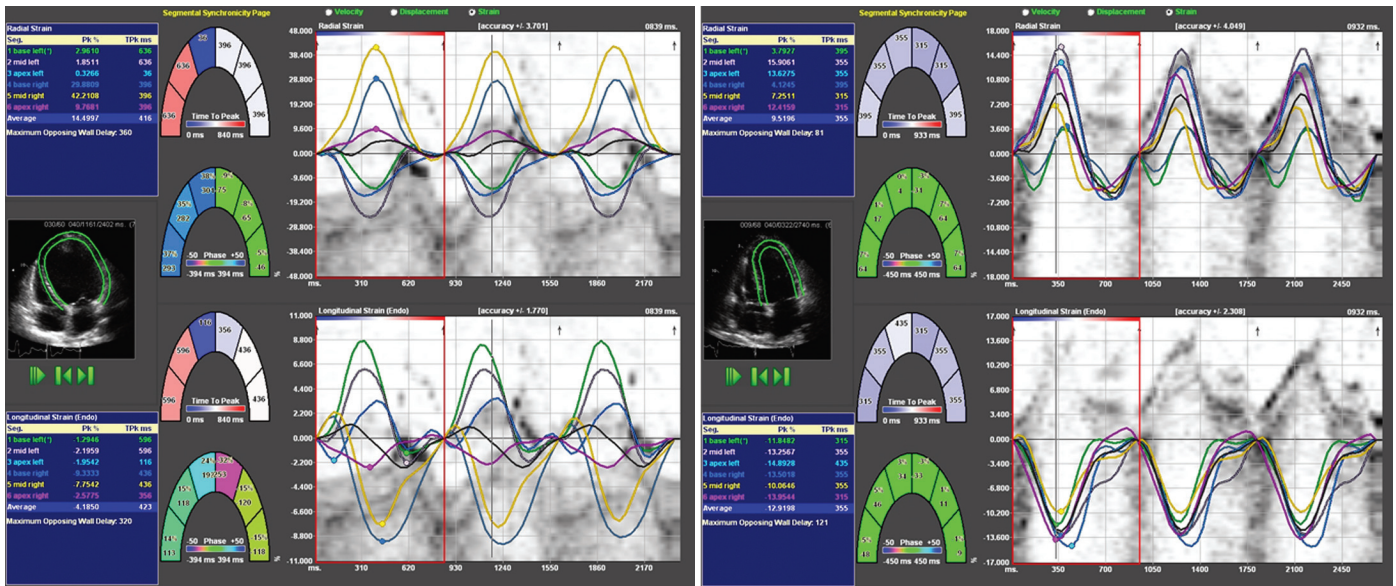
Assessment of myocardial strain from the apical four-chamber view. Average radial and longitudinal strain is calculated from six different regions in the ventricle. The waveforms depicted demonstrate both the timing and magnitude of peak strain in these regions. The left panel shows a patient with cardiomyopathy before therapy with a cardiac resynchronization device. The right panel shows same patient after 12 months of CRT with dramatic improvement in ventricular synchrony.
